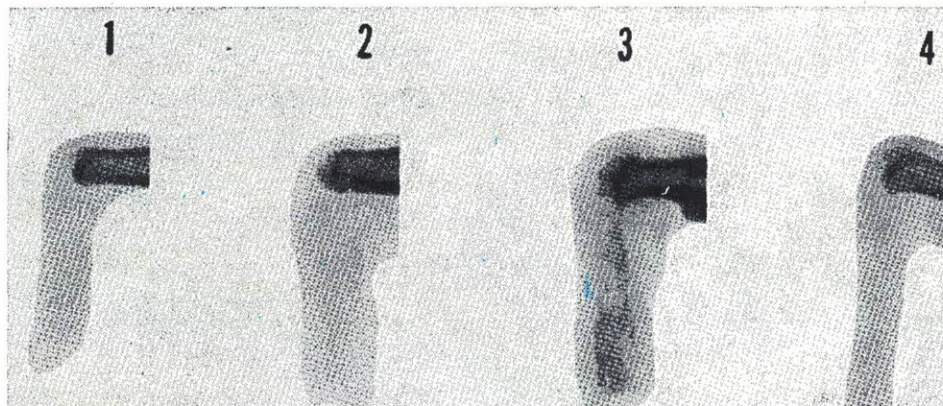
X-rays of Induced Fibro-osseous Proliferation
